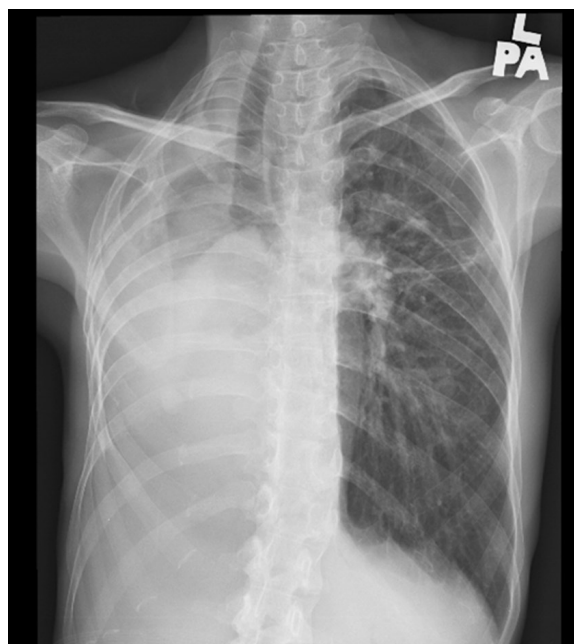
Post-pneumonectomy PA chest radiograph of the patient showing the marked mediastinal shift (including the tracheal) to the right thoracic cavity, with compensatory hyperinflation of the left lung.
